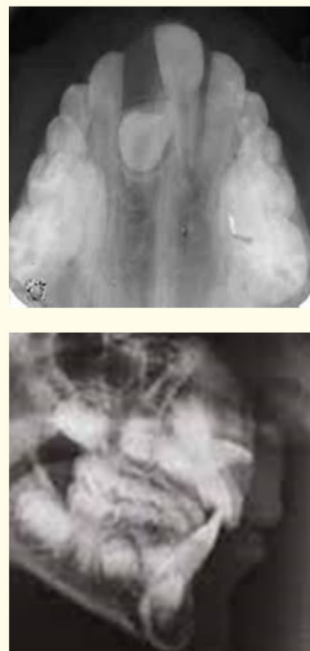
Examples of Dilacerated upper permanent incisors on an upper occlusal x-ray and a cephalometric one.
